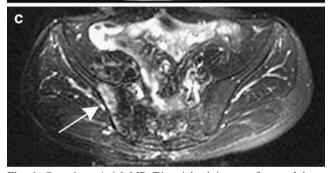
Case 1. a Axial MR T1-weighted image of normal bone marrow. Five months later, a right iliac bone marrow lesion had appeared, on b T1 SE (*arrow*) and c T1 FSE fat pre-saturated (*arrow*) images
